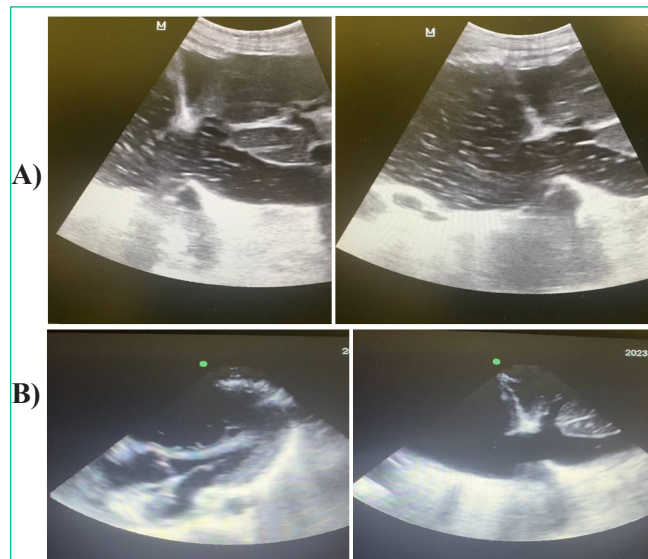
Bedside echocardiography. Before (A) and after (B) thrombolytic therapy.
